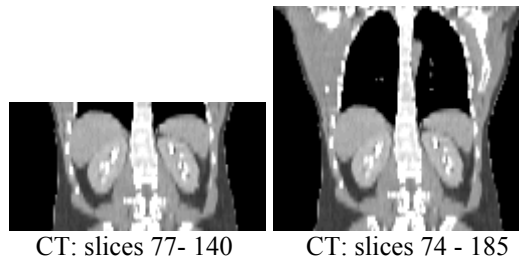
A coronal section through the restricted CT volume that excludes the lungs (left), compared to the volume used in previous studies (right). The range of slice numbers is shown in square brackets.
